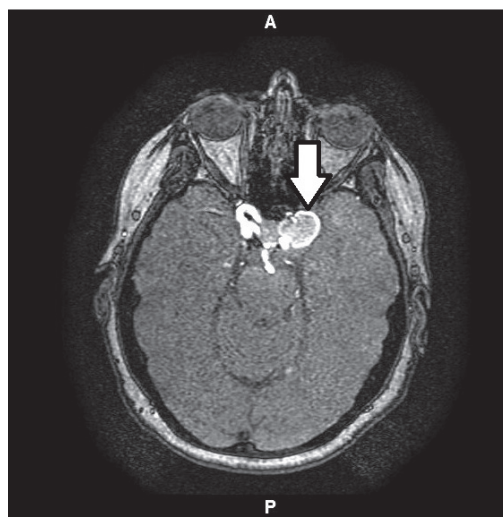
Axial MRI of patient with large, symptomatic cavernous carotid segment aneurysm (arrow).
